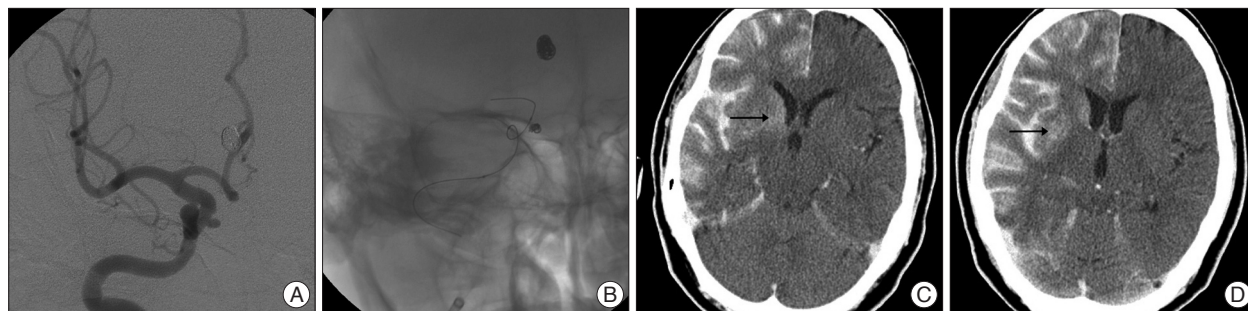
A and B : Procedural angiographic images in case 2. C and D : Immediate post-embolization non-contrast CT scan showing strong cortical hyperintensity of the right frontoparietal lobe and high density in the right striatum (arrow). CT : computed tomography.
